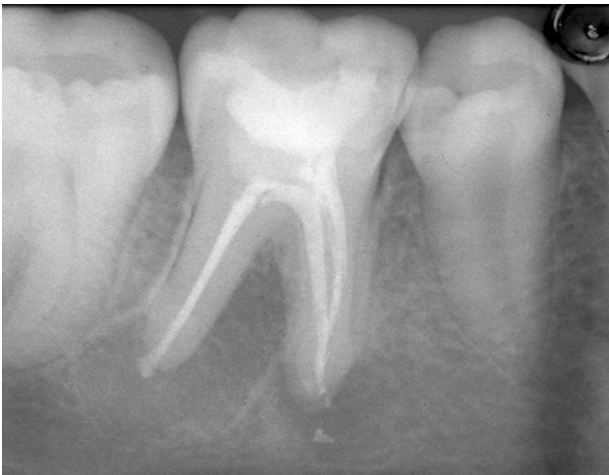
Post-operative radiograph of 4.6. Obturation with thermoplasticized guttapercha after activation and heating of irrigants.
